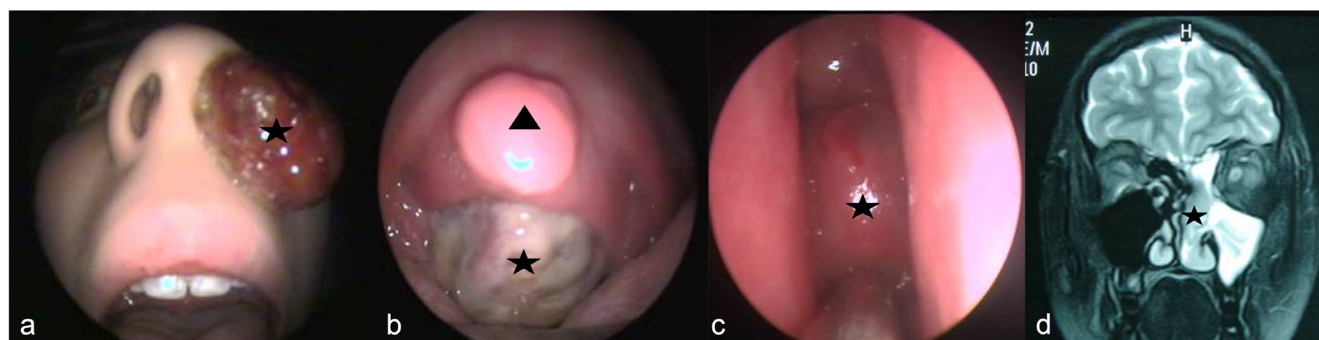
Left sided glomangiopericytoma a) endoscopic view of adolescent patient at presentation b) tumour extending to posterior pharynx endoscopic view inside oral cavity tumour visible in posterior to uvula c) endoscopic view before last revision surgery left side sinonasal mass covered with mucosa d) preoperative MRI before last surgery coronal view showing tumour attaching to the skull base.
